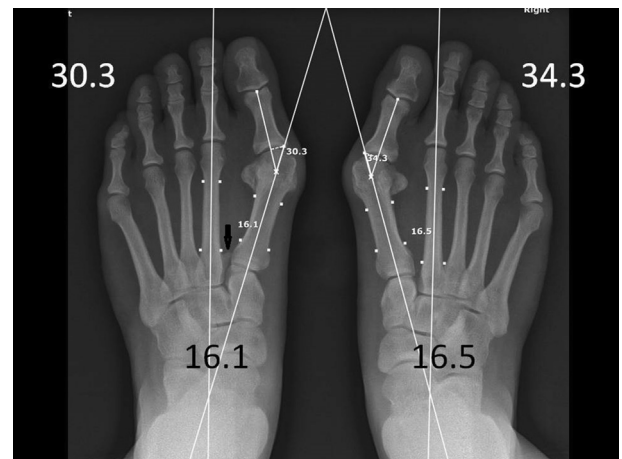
Preoperative standing AP-view X-ray. The feet revealed severe MPV deformities with left intermetatarsal angle (IMA) of 16.1° and right IMA of 16.5°, complete fibular sesamoid dissociation and the large os intermetatarsaleum (black arrow) of the left foot. MPV = metatarsus primus varus.
